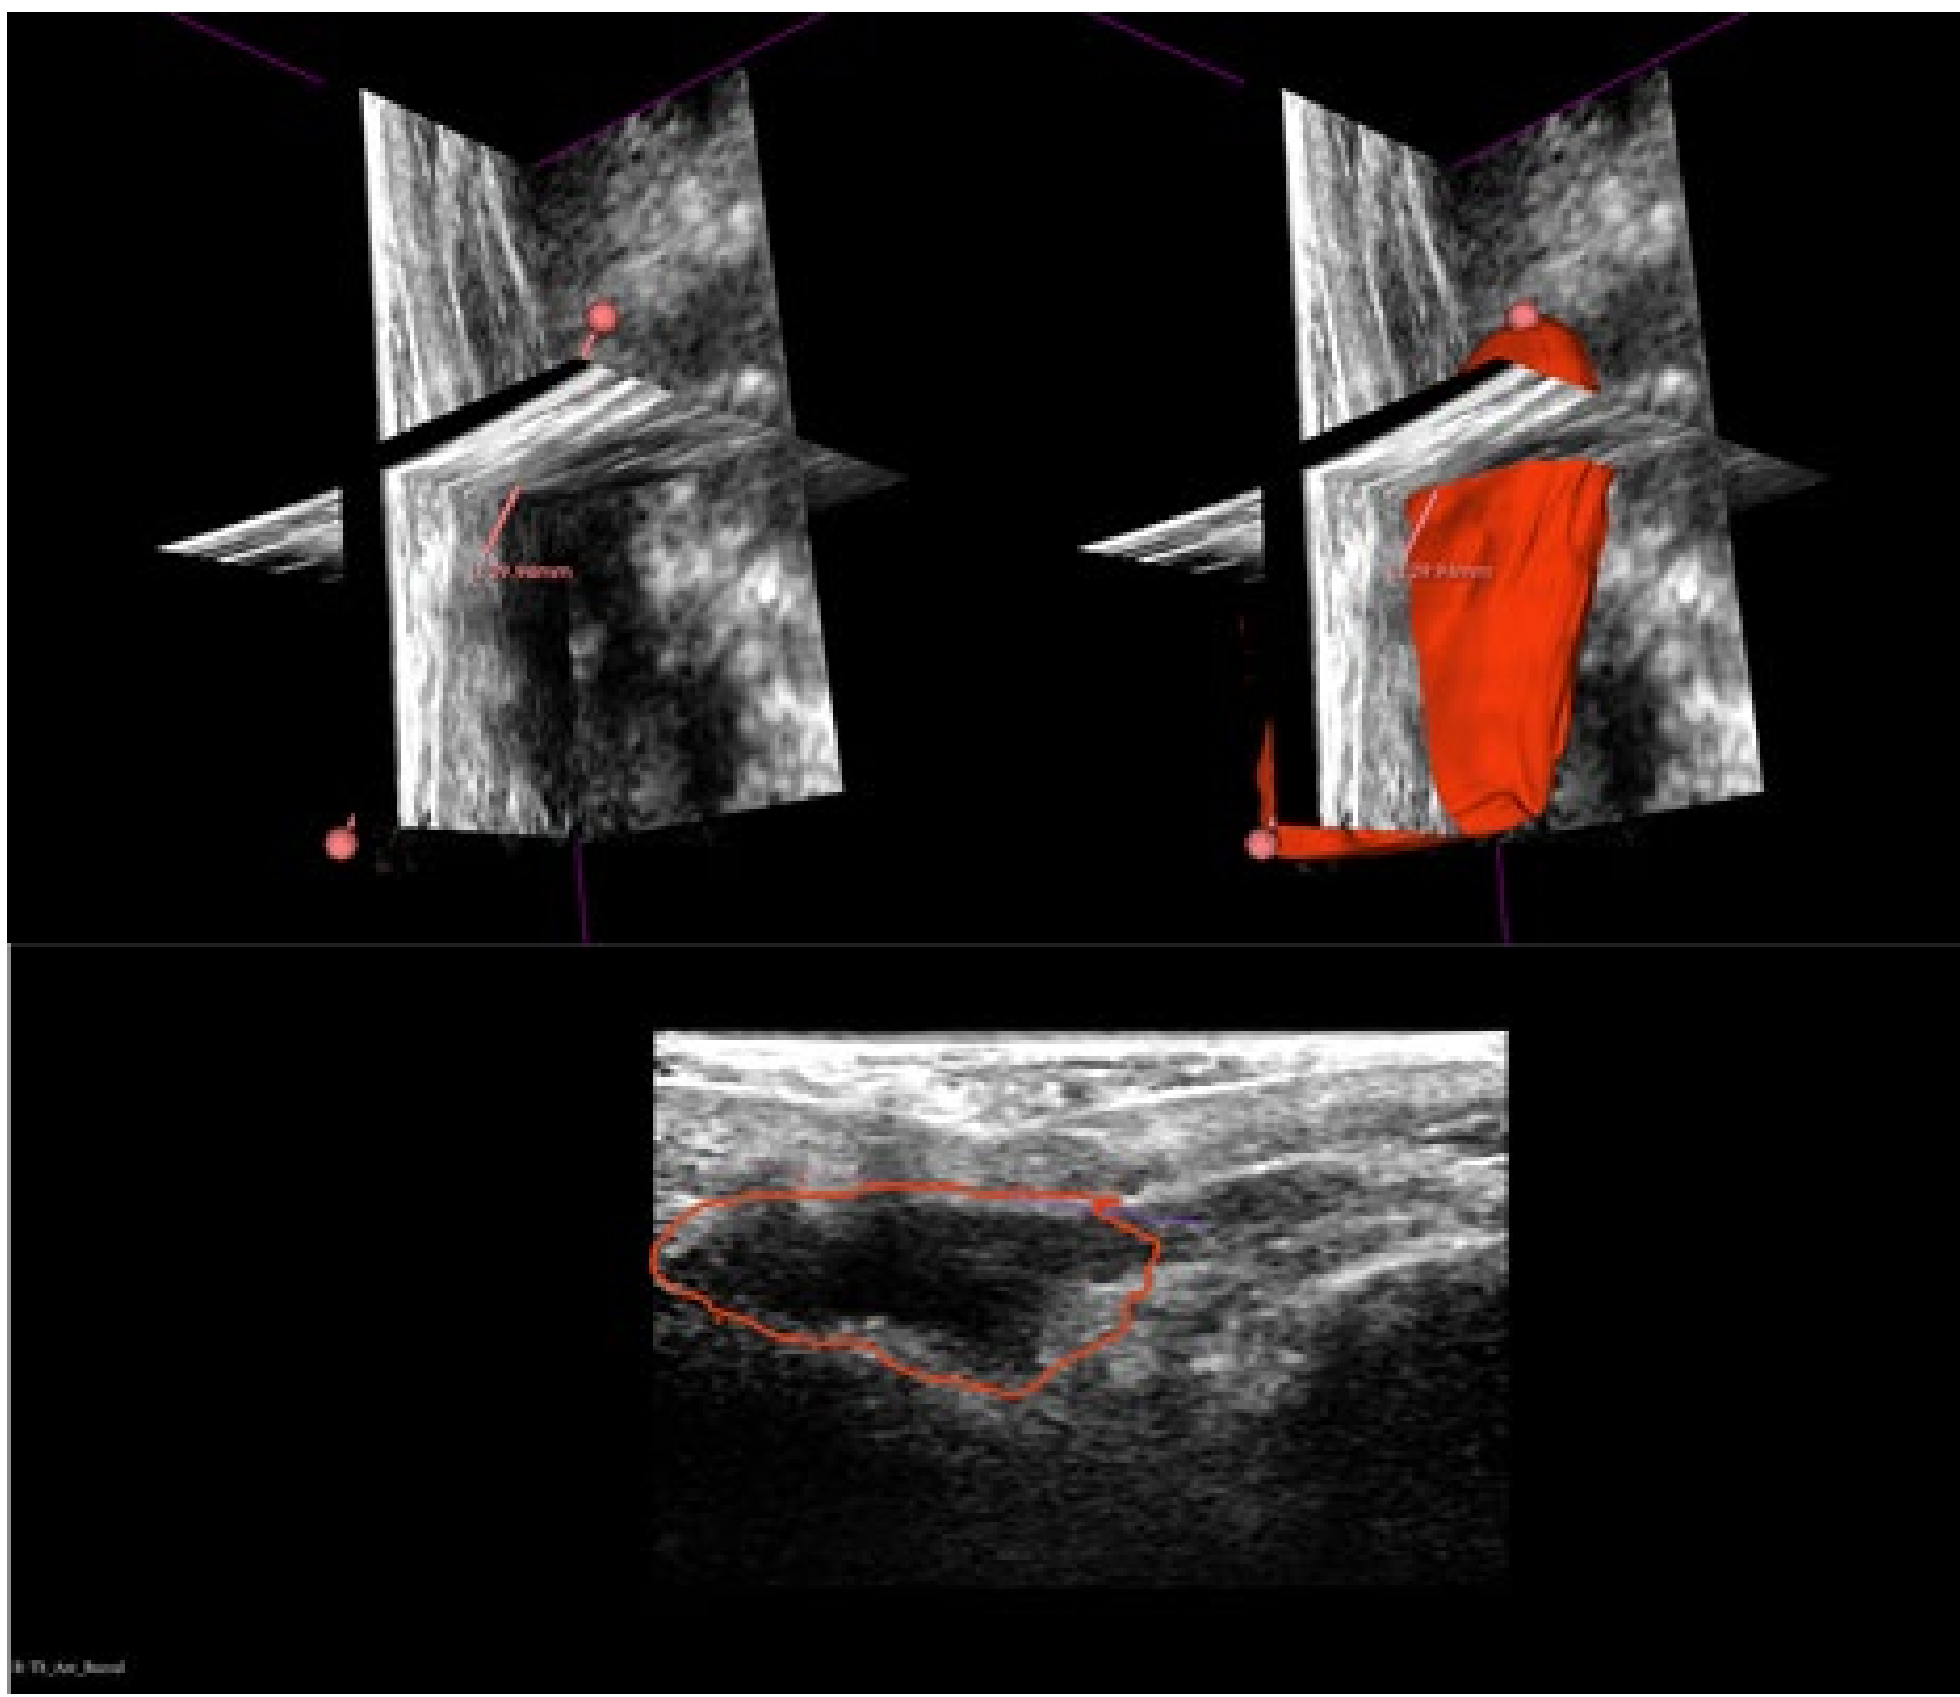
Three-dimensional ultrasound (3DUS) visualization of a 2.5 cm squamous cell carcinoma in the right floor of the mouth. (A) Volumetric rendering of the submental scan data visualized in 3D Slicer. (B) Corresponding 3D view with the solid surface segmentation applied, delineating the tumor's extension across the midline. (C) Oblique cross-sectional view revealing the tumor as a distinct hypoechoic (dark) region, which served as the anatomical basis for the volumetric quantification.
